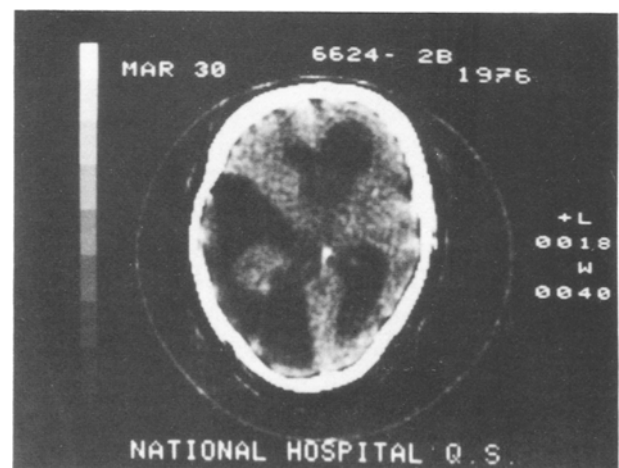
Unenhanced CT scan of patient showing a huge peripheral extratumoural cyst corresponding to type 3 as defined by Nauta *et al.*⁴³
